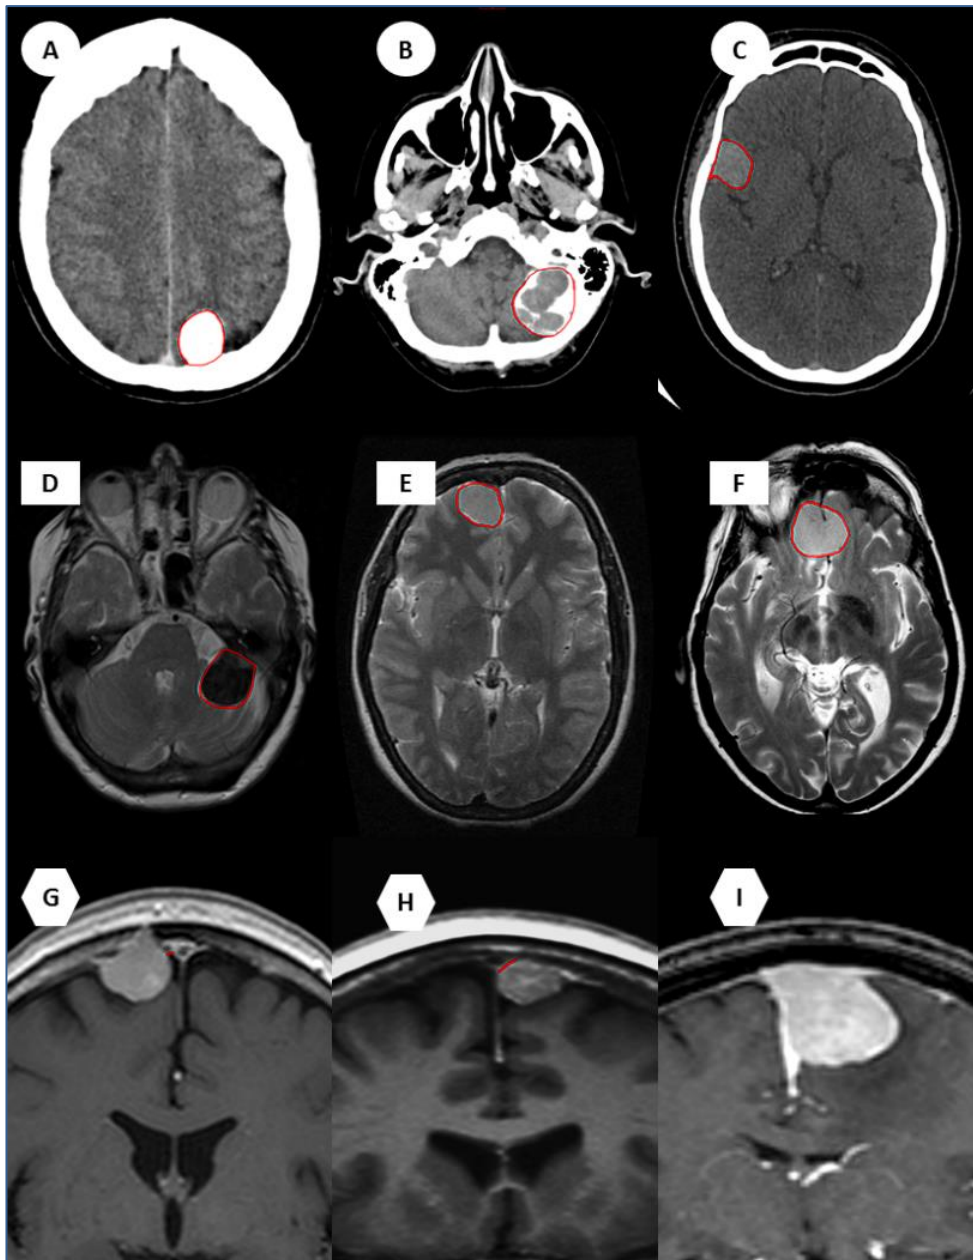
(A-C) Non-contrast axial CT scans demonstrating the 3 levels of meningioma calcification (circle). (A) Diffuse calcification. (B) Partial calcification. (C) Absence of calcification. (D-F) T2 MR axial sequences showing the 3 levels of tumour intensity (circle). (D) Hypointense. (E) Isointense. (F) Hyperintense. (G-I) T1-weighted MR with gadolinium (contrast) showing the relationship between the meningioma and the nearby venous sinus (SSS). (G) Separate as there's no clear attachment to the sinus wall. (H) In direct contact with the lateral wall of the sinus. (I) Clear macroscopic distortion and invasion of the sinus.
